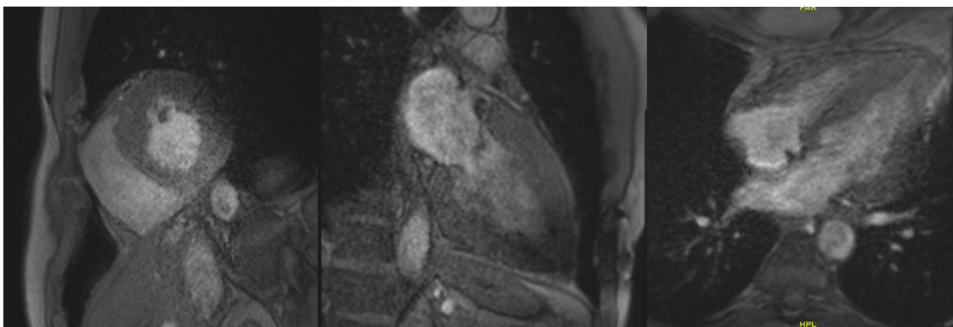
CMR shows severely increased LV wall thickness. Maximal thickness at mid anteroseptum is 2.4 cm, posterior wall thickness is 1.8 cm. Native myocardial T1 Value is reduced at 875 ms. Reduced noncontrast myocardial T1 values are highly sensitive and specific for FD in patients with undifferentiated LV hypertrophy.² Gadolinium was not used in this patient due to chronic kidney disease. Patients with FD can have pathologic late gadolinium enhancement. Late gadolinium enhancement is often present in the inferolateral LV wall but atypical patterns can also exist.⁴ Biventricular hypertrophy is also noted on CMR. Artifact in lateral wall of the LV. CMR = Cardiac magnetic resonance imaging; FD = Fabry disease; LV = left ventricular.
